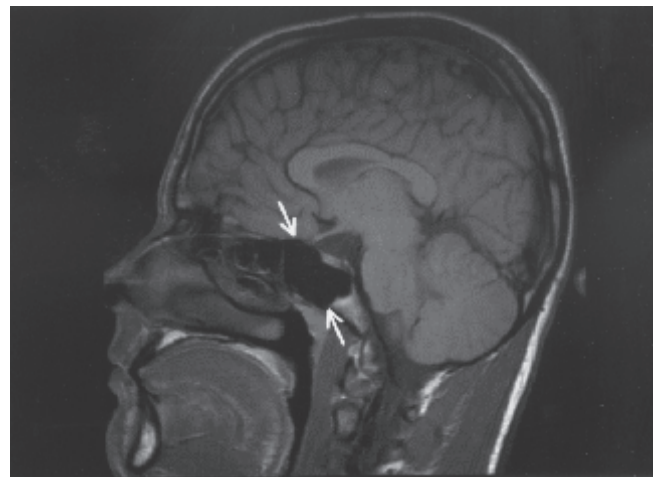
Midsagittal T1-weighted MR-image (650/30) shows complete pneumatization of the sphenoid sinus in a 14-year old boy (arrows).
